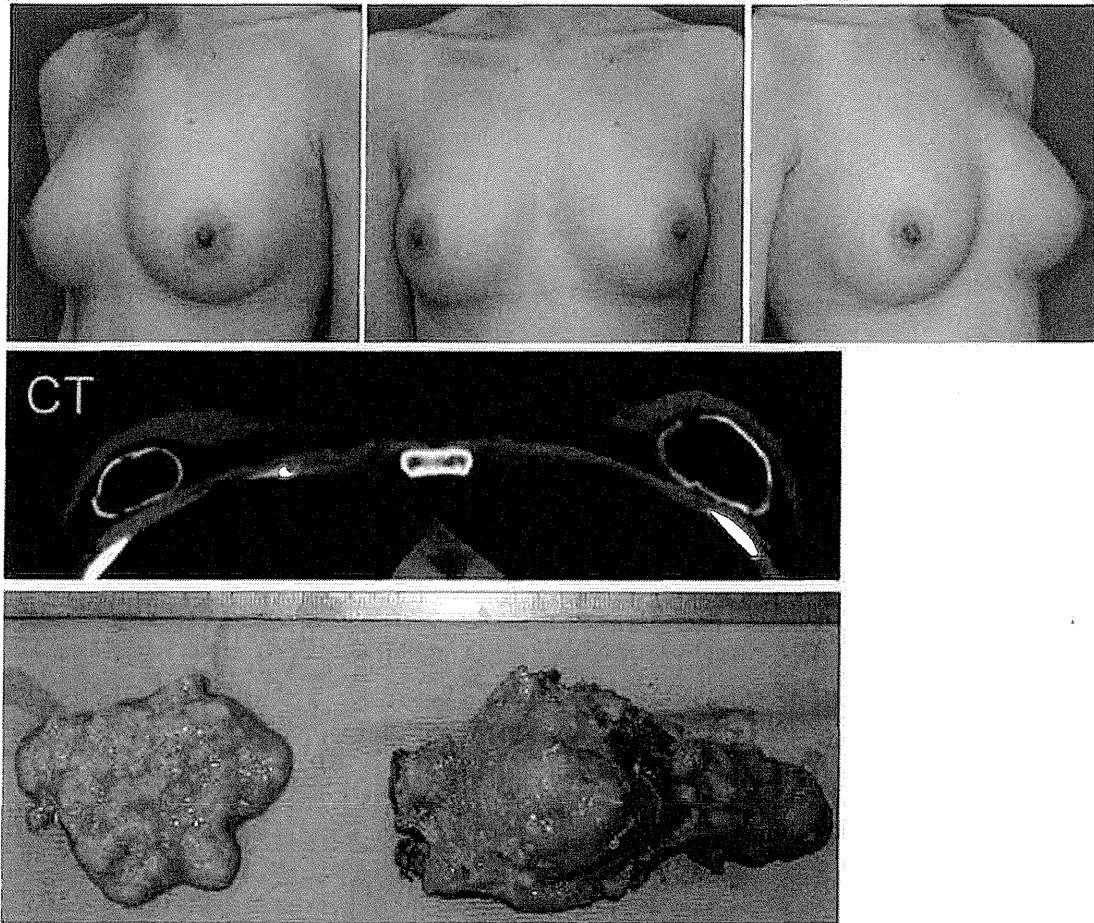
A case of oil cysts. A 24-year-old woman underwent fat grafting for cosmetic breast augmentation 2 years earlier. She recognized hardness of the entire breast at 6 months and gradually recognized tenderness and abnormal sensations. (*Top*) She had well-projected breasts with tight skin. The contour of the upper pole looked similar to a breast with implant contracture. (*Middle*) Preoperative computed tomography (CT) scan showed that there was a single large calcified oil cyst under each mammary gland. It was suspected that 100 to 200 mL of fat tissue had been introduced in a bolus injection before. (*Bottom*) Removed oil cysts were filled with muddy content caused by fat necrosis. The oil cyst wall had innermost and outermost fibrous layers. (*Adapted from* Mineda K, Kuno S, Kato H, et al. Chronic inflammation and progressive calcification as a result of fat necrosis: the worst outcome in fat grafting. *Plast Reconstr Surg* 2014;133:1064–72; with permission.)
